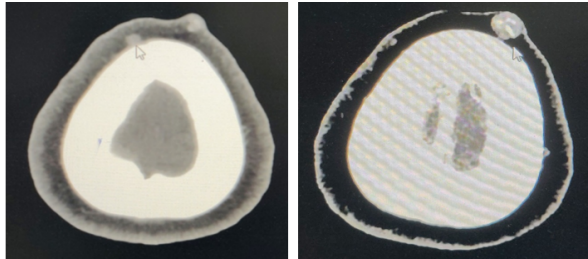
4B: Axial sections of CT brain shows two small partially calcified nodular lesions in the subcutaneous plane of scalp in the high frontal region.
